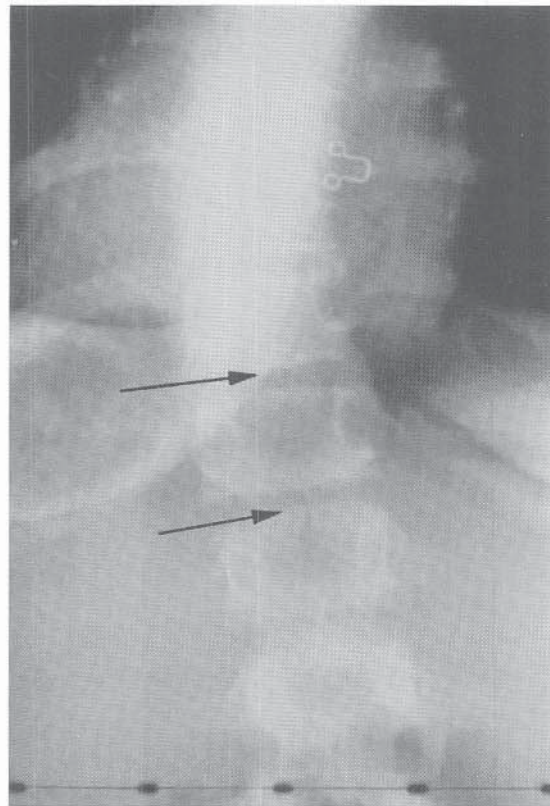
PA radiograph of the spine of a 12-year-old girl. The spinous processes of T11 and T12 were not detectable on palpation. The radiograph shows spina bifida occulta at the same levels (arrows).
